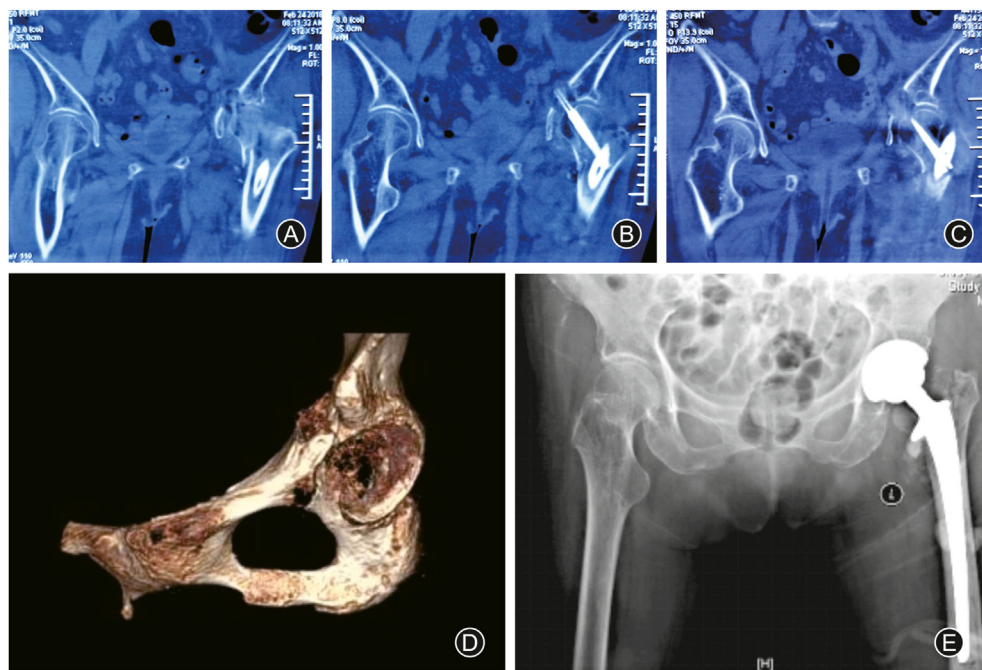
(A–D) CT scan at 8 weeks after surgery showing the tip of helical blade in the pelvic and non-union fracture; (A–C) Three consecutive CT figures; (D) 3-D reconstruction of the acetabulum; (E) Anteroposterior X-rays of a cemented total hip arthroplasty after removal of the proximal femoral nail anti-rotation.
